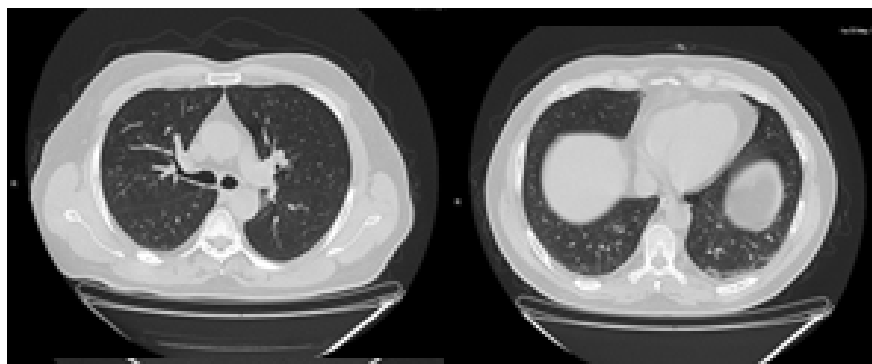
Thorax CT on the 45th day. Ground glass and fibrotic lesions, right upper thin-walled cystic lesion were determined
